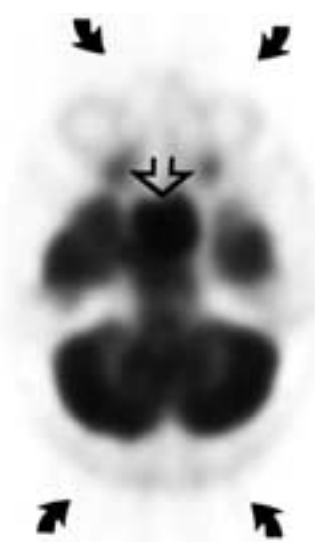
An FDG PET examination performed on a patient with nasopharyngeal carcinoma and reconstructed with filtered backprojection demonstrates a focus of intense activity in the nasopharynx (*open arrow*). Note that spray artifact is prominent around the periphery of the image (*arrows*).
